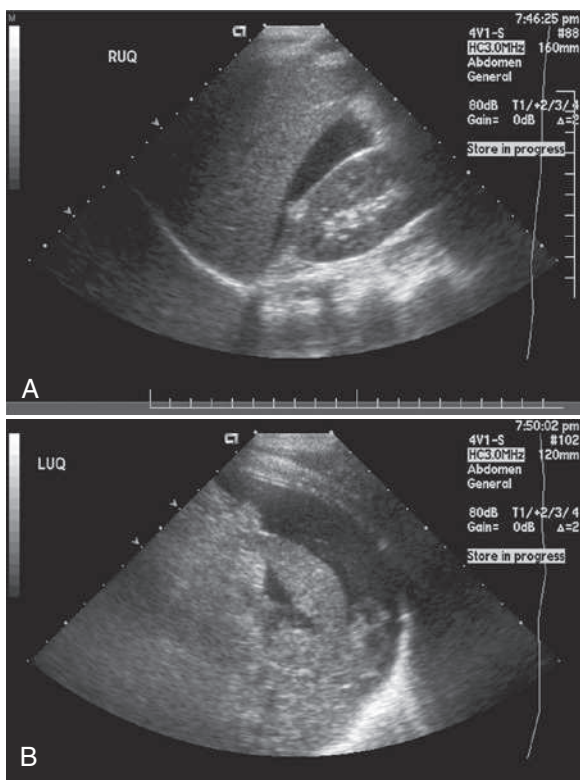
A, Ultrasound image demonstrating fluid in Morison's pouch. B, Fluid around the spleen.
